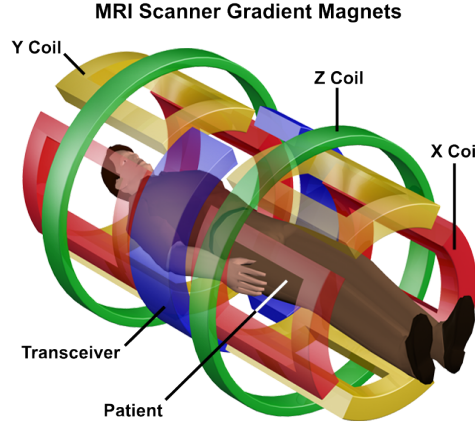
A conceptual visualization of the gradient coils of an MRI scanner.
